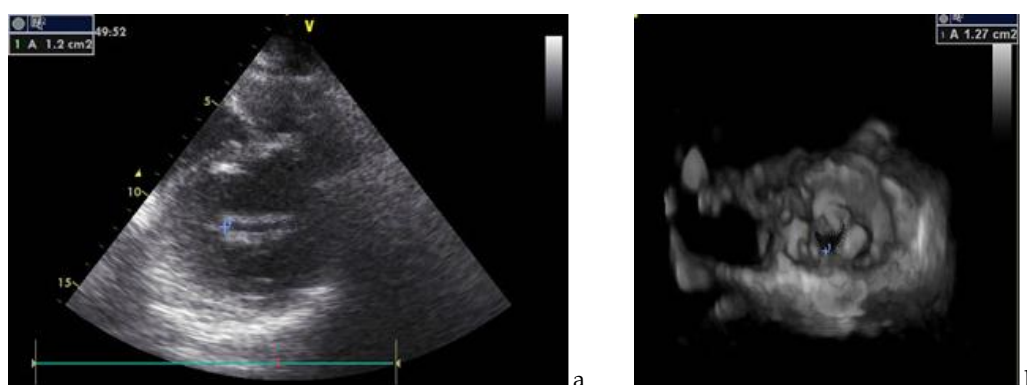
Mitral opening area determined by bidimensional and three-dimensional transthoracic echocardiographic study in a patient with mitral stenosis.
